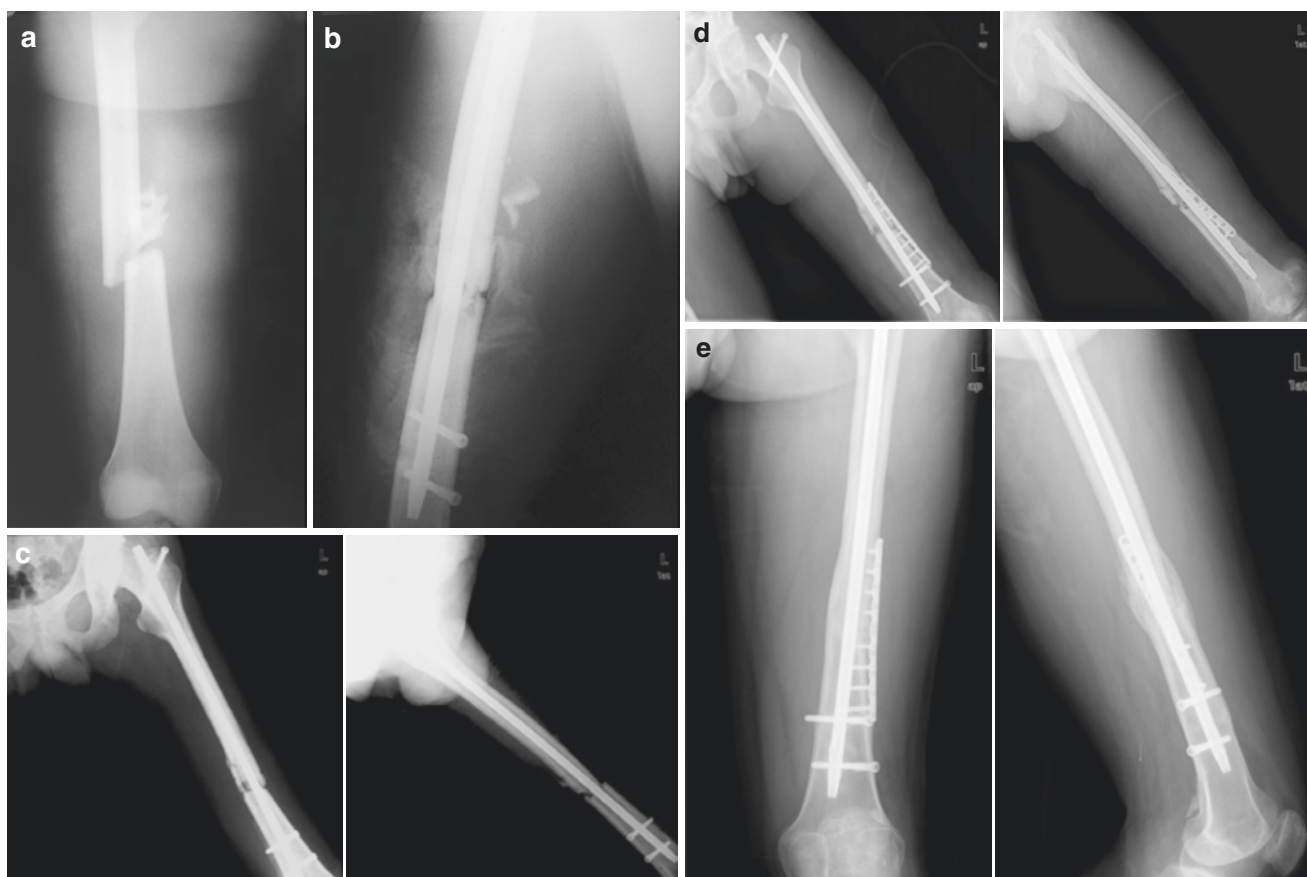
The patient received lateral single-plate fixation for a femoral shaft fracture; however, the medial cortical defect resulted in broken of the plate and nonunion (the original preoperative and immediate postoperative radiographs were missing). (a) AP and lateral radiographs obtained after the plate was broken: The medial cortical bone was
